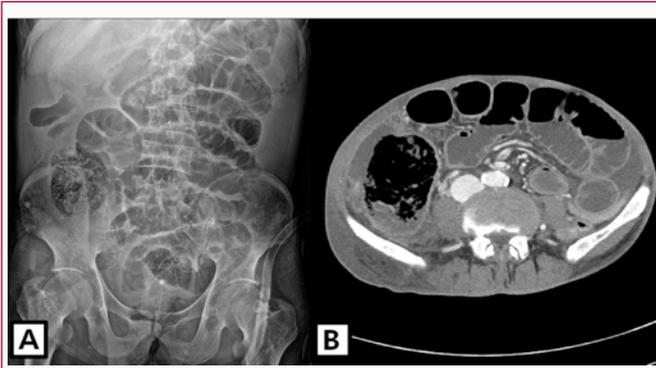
(A) Abdominal supine X-ray of ileus. (B) Axial section of abdomen CT showing edematous wall thickening of ascending colon with complicated fluid collection around the cecum.
